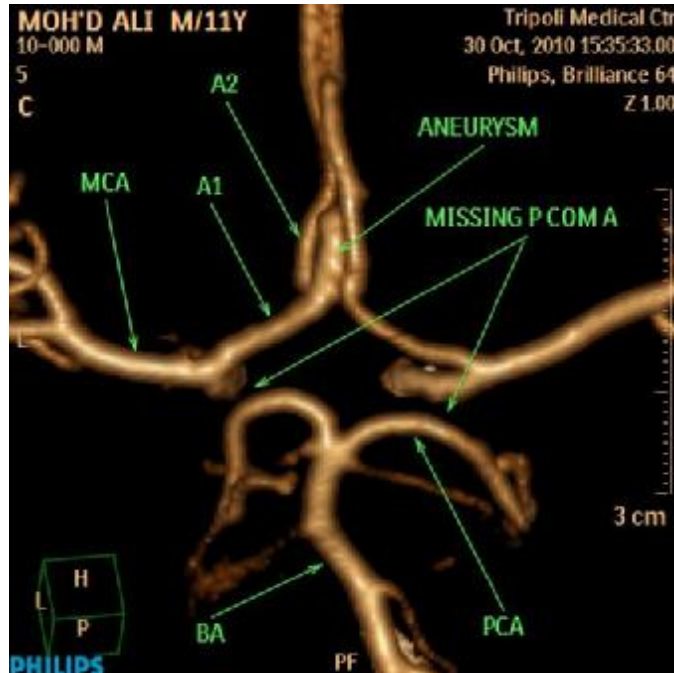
CTA shows bilateral missing of PcomA, hypoplastic RA1 and AcomA aneurysm.
